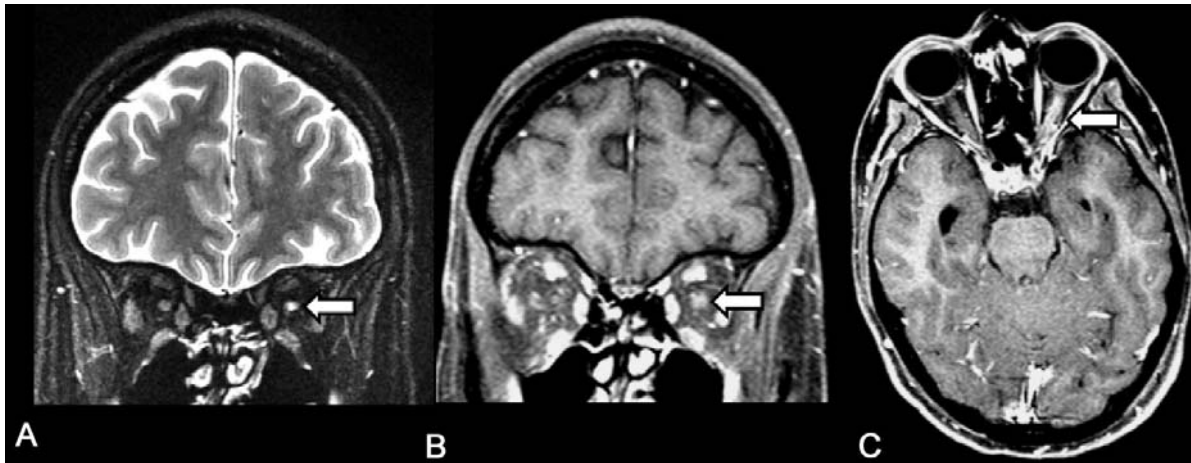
MRI findings in acute optic neuritis involving the left optic nerve: A. Coronal short tau inversion recovery sequence shows an increased signal in the left optic nerve (arrow) compared to the fellow right optic nerve. B. Contrast-enhanced spin echo T1-weighted, fat-suppressed coronal MRI through the orbits shows enlargement and contrast enhancement of the left optic nerve (arrow). C. Contrast-enhanced spin echo T1-weighted, fat-suppressed axial MRI through the orbits shows enlargement and contrast enhancement of the left optic (arrow).
